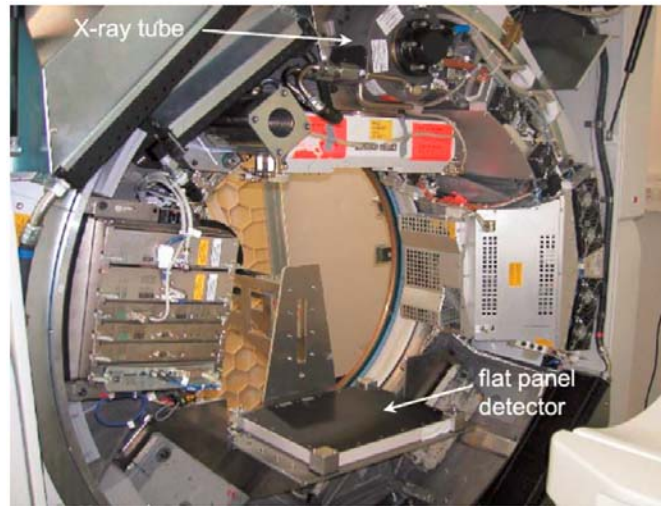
Prototype of seventh generation CT scanner
